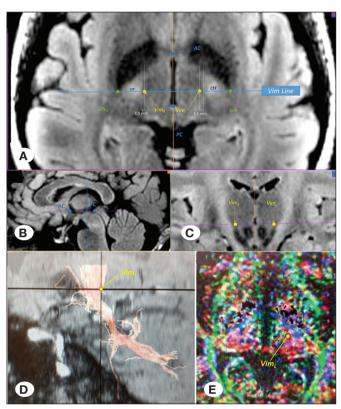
VIM point determination in MRI (T2 flair sequences) using the VIM line technique. A) axial; B) sagittal; C) coronal; D) dentatorubrothalamic track in diffusion tensor imaging (DTI)/ diffusion-weighted imaging (DWI) sequence; E) region of interest (ROI) placement in DTI sequence. AC: anterior commissure, PC: posterior commissure, CST: cerebrospinal track, GPe,: left external globus pallidus, GPe<sub>R</sub>: right external globus pallidus, VIM,: left ventral intermediate nucleus of the thalamus, VIM,: right ventral intermediate nucleus of the thalamus.
